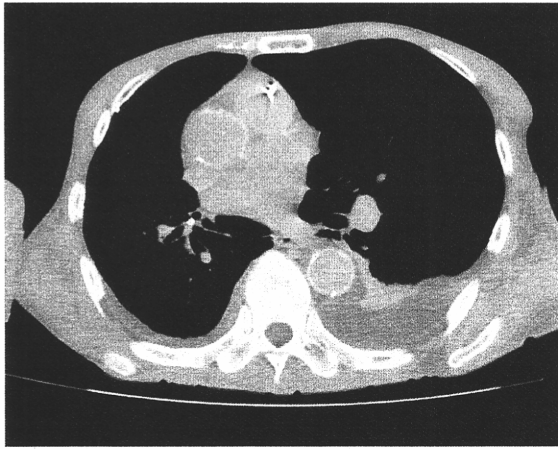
Computed tomogram shows displacement of the great arteries into the right chest. Left pleural effusion is present.
